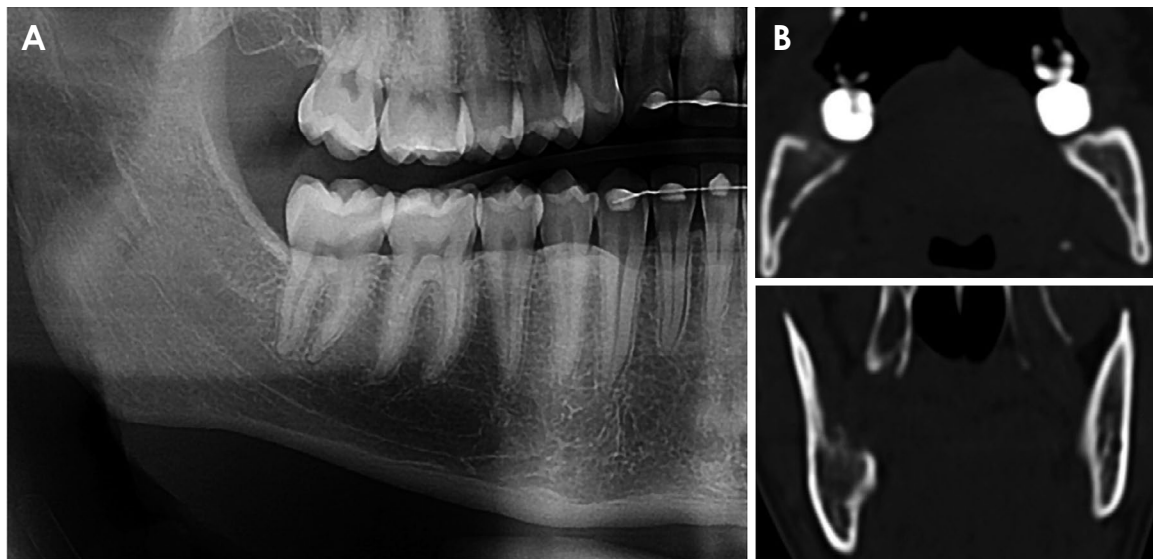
A. A cropped panoramic radiograph reveals thinning of the upper cortical bone around the alveolar nerve located distal to the second molar. B. Computed tomographic images reveal an irregular cortical erosion of the alveolar bone distal to the second molar.
